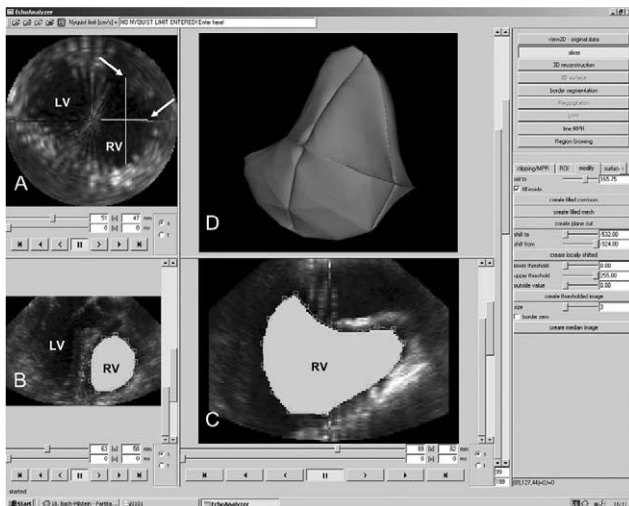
Segmentation procedure of right ventricular cavity volume by the EchoAnalyzer<sup>®</sup>, a multitask system developed at our institution for 3D reconstruction and measurements of echocardiographic datasets. Panels A, B and C show the original echo data of right ventricle in three orthogonal planes. In panels B and C right endocardial contours are outlined as white areas (RV). In panel A these two areas can be seen (arrowheads). Panel D shows the correspondent 3D reconstruction of right ventricular volume obtained by the segmentation of three non-parallel slices. RV, right ventricle; LV, left ventricle.
